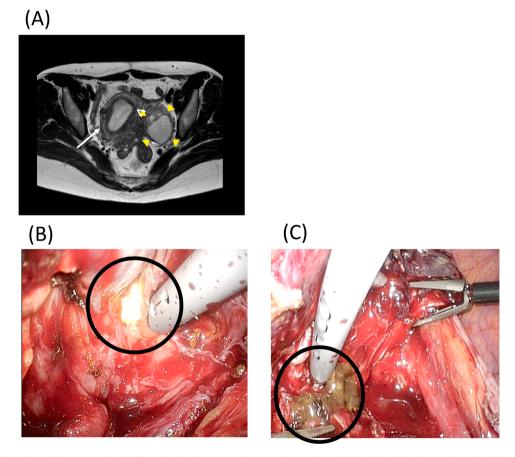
Preoperative imaging and intraoperative findings during laparoscopic surgery in patient 1;(A) Axial pelvic T2W MR imaging shows a thickened capsule around cysts in the left ovary; the contents are suspicious of the abscess. An arrow indicates the uterus, and a triangle characterizes the left ovarian cyst. (B) Yellowish-white fluid flows from the left ovary. A black circle indicates the rupture point of the cyst. (C) Chocolate-like fluid is flowing from the right ovary. A black circle indicates the rupture point of the cyst.
